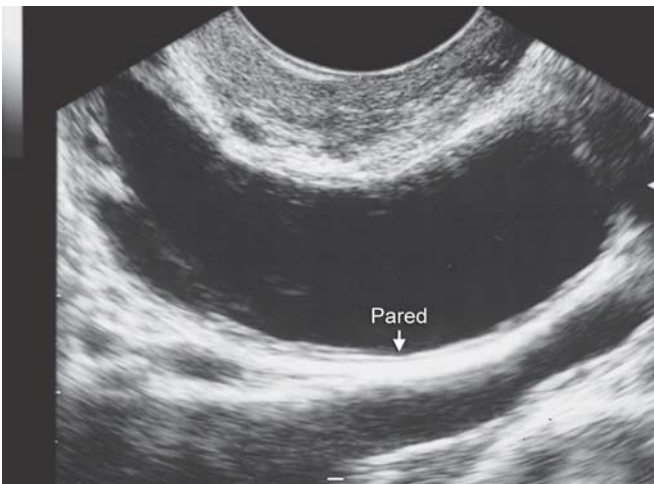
Pyosalpinx—Incomplete septa. When the fallopian tube is dilated and is doubled, the wall provokes a sonographic sign of incomplete septa. Echorefringent material in the interior of the fallopian tube
